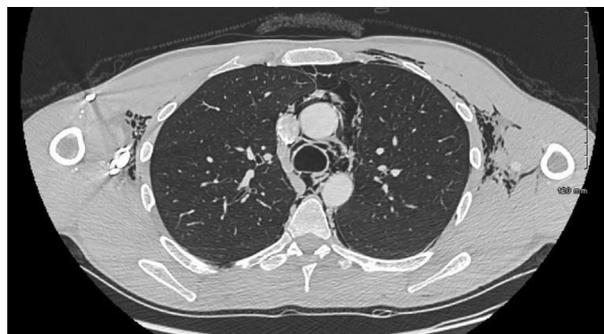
Axial computed tomogram showing emphysema extending to axillary spaces and mediastinum without any compression of the airways.
